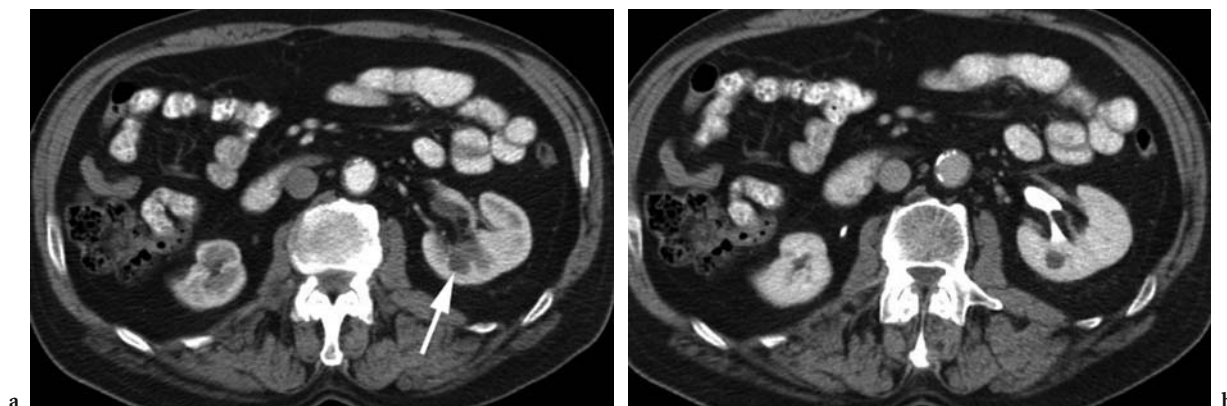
Conspicuity of small medullary masses on early vs later phase of excretion in a 47-year-old man undergoing CT for evaluation of hematuria. a Axial contrast-enhanced CT scan at early corticomedullary differentiation phase of contrast excretion shows 1 cm hypodensity in the posterior left kidney (*arrow*) which blends into the unopacified medulla. b The lesion is easily identified on excretory phase imaging and reconstructed thin sections determined it is a cyst.
